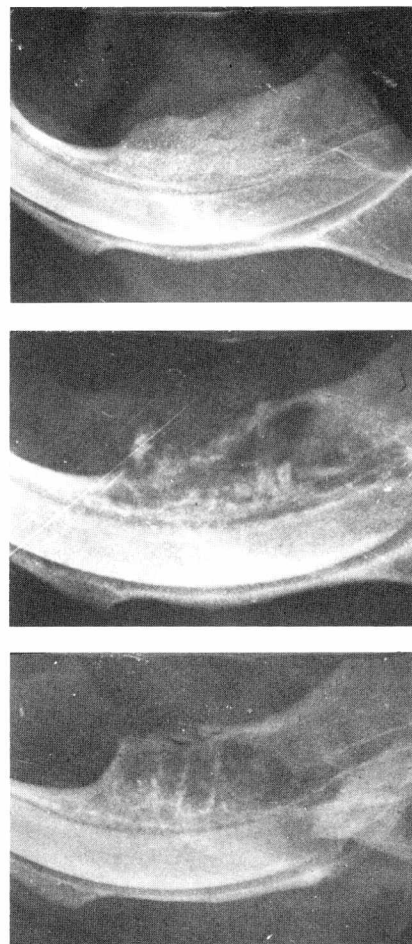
Radiographic appearance 14 days post-extraction. Upper: control, medium: irradiated; lower: irradiated and injected with EHDP.
